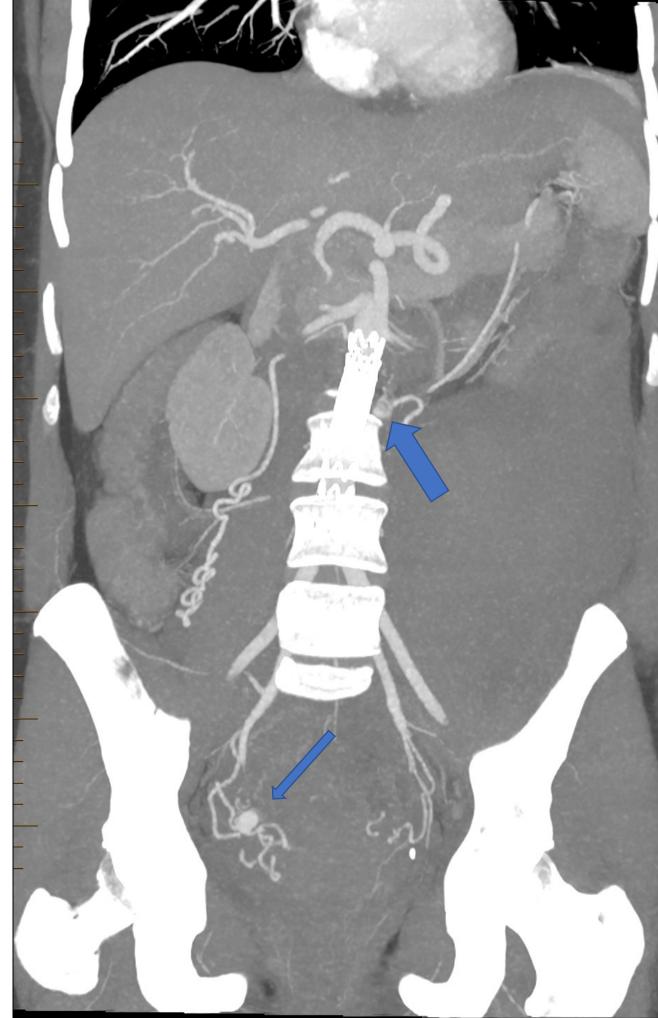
2 days post admission: CT angiogram post distal aorta stenting procedure (seen midline). The thick arrow represents the left ovarian artery pseudoaneurysm (18 x 14mm). The thin arrow representing an incidental finding of an unruptured right uterine artery pseudoaneurysm (13 x 11mm).
